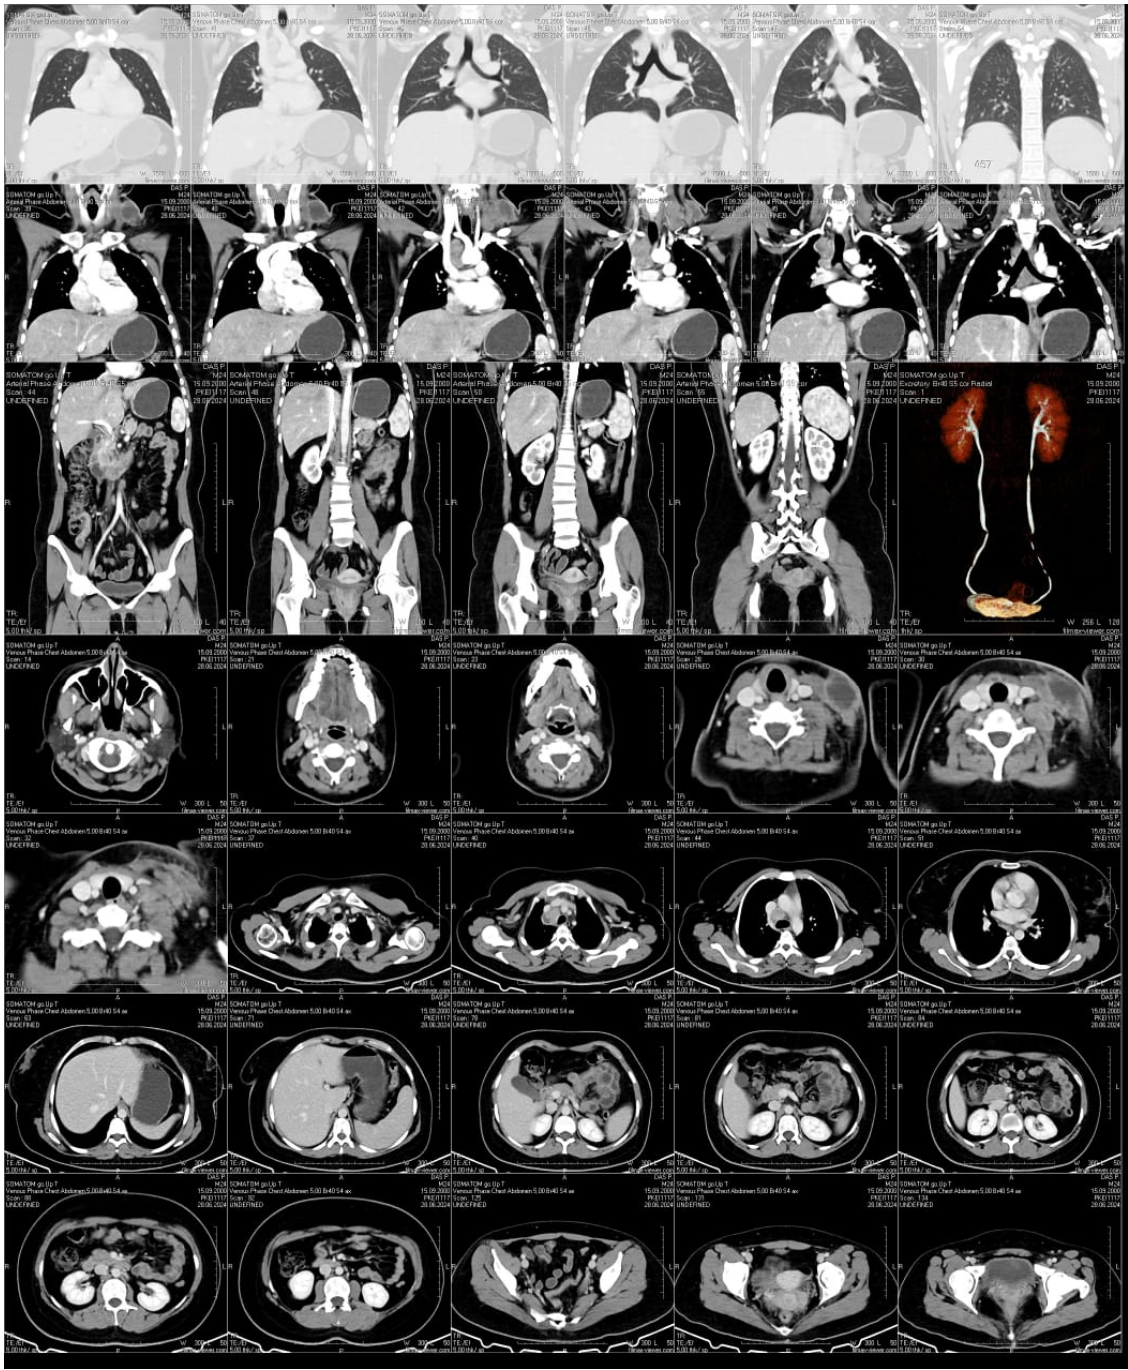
Contrast-Enhanced CT Scan.
